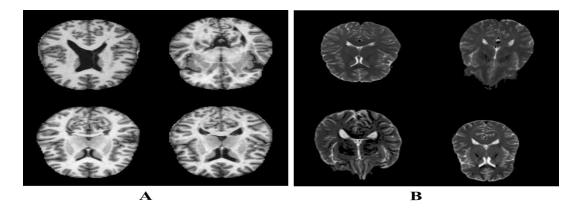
MRI images of the two classes of the dataset used, (A) the healthy, and (B) for PD.
